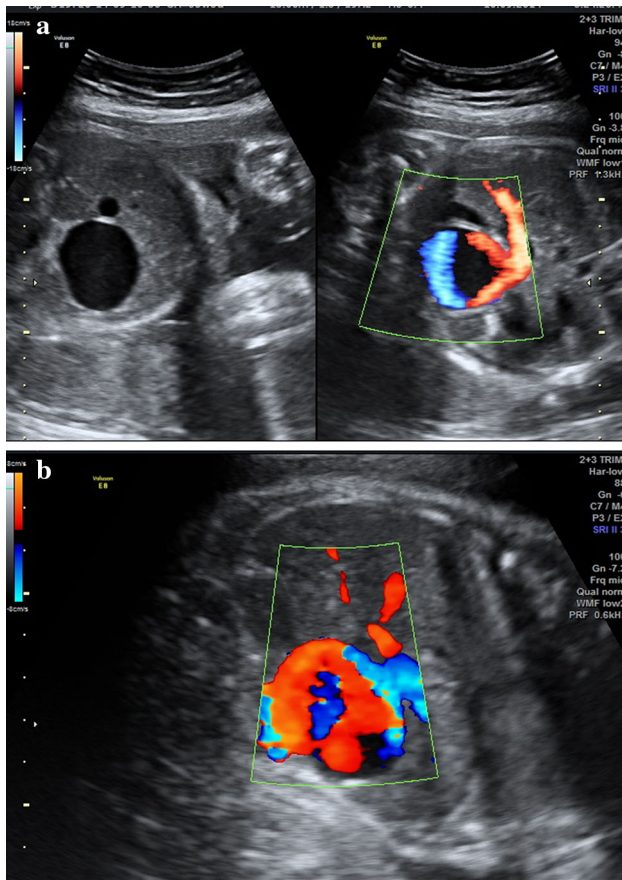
a, b Repeat ultrasound evaluation at 33–34 weeks of gestation showing increase in the dimension of the umbilical vein varix
